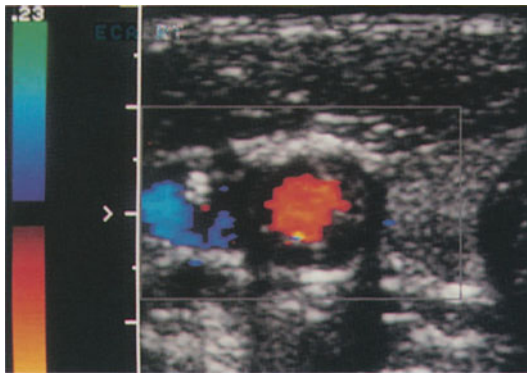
Transverse sonogram of CCA shows a concentric stenosis with atheromatous lesions of low echodensity and irregular surface characteristics. The color-coded residual lumen shows no evidence of increased flow velocity or turbulence
